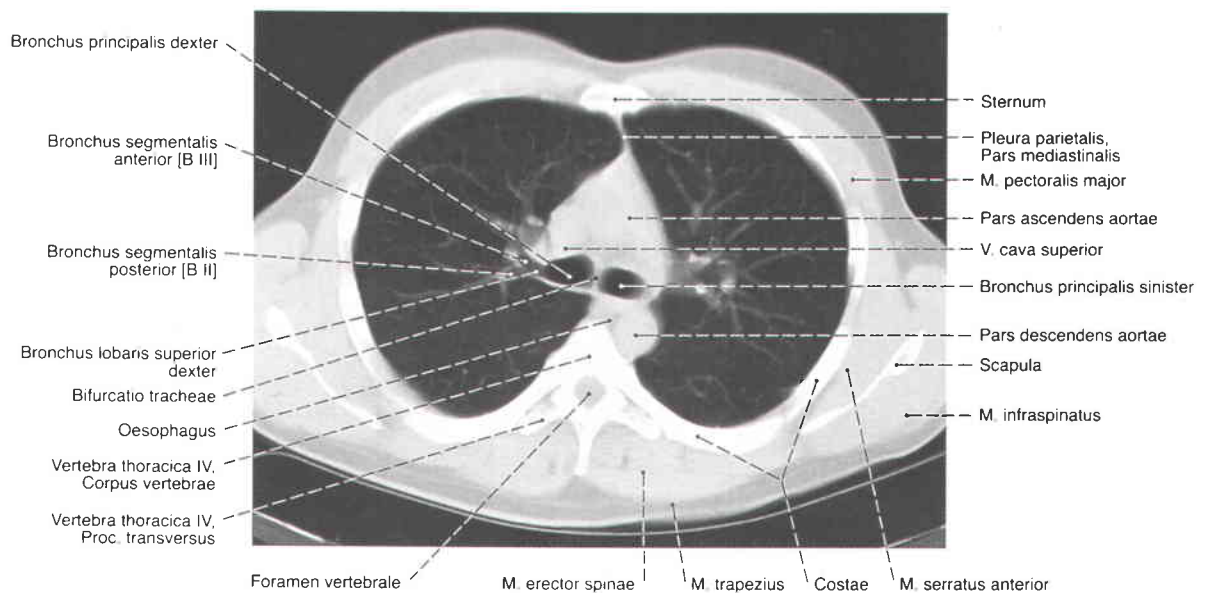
Thoracic cavity, Cavitas thoracis; computed tomography (CT) at the level of the bifurcation of the trachea. Depending on the electronic
